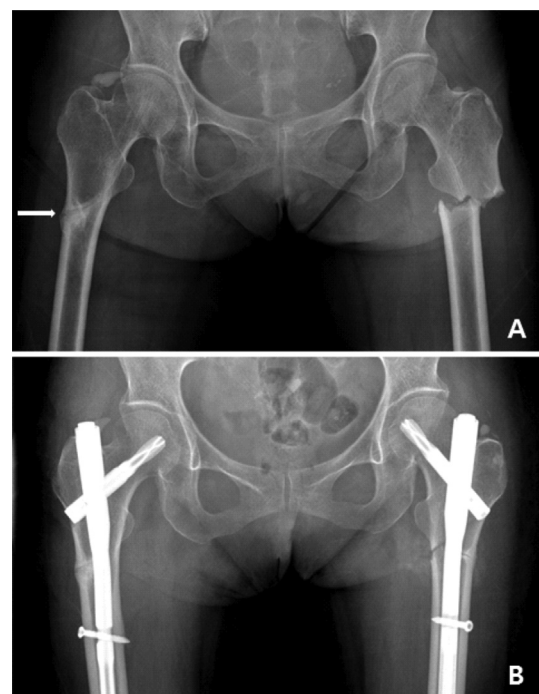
Hip AP view shows complete fracture of left subtrochanter and incomplete fracture (white arrow) of right subtrochanter (A). Immediate postoperative radiography (B).
